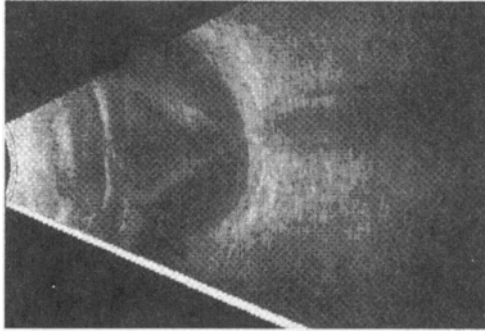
Ultrasound examination shows a total retinal detachment of the right eye
